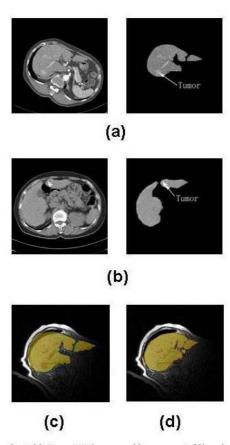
Example 1. (a) Open MR image and its segmented liver image; (b) CT image and its segmented liver image; (c) rigid registration result; (d) FFD-based non-rigid registration result.
